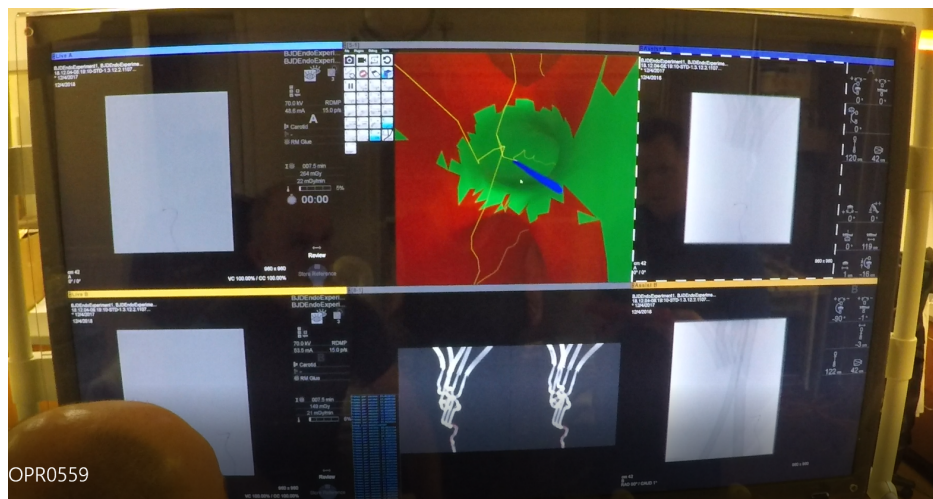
Video capture of the C-Arm angiography x-ray system demonstrating integrated real time 4D-assisted during a navigational task performed by a participant. Conventional biplane fluoroscopy A plane (top) and B plane (bottom) images top and bottom left. The top center display demonstrates the 4D endoscopic display while the bottom center display demonstrates the 4D external view, both generated from live biplane fluoroscopy images at 15 fps. The guide wire is rendered blue in the endoscopic display and red in the external view display. The unsubtracted A plane (top) and B plane (bottom) are shown right. The display demonstrates various view types, allowing a view of the static 3D-DSA.
